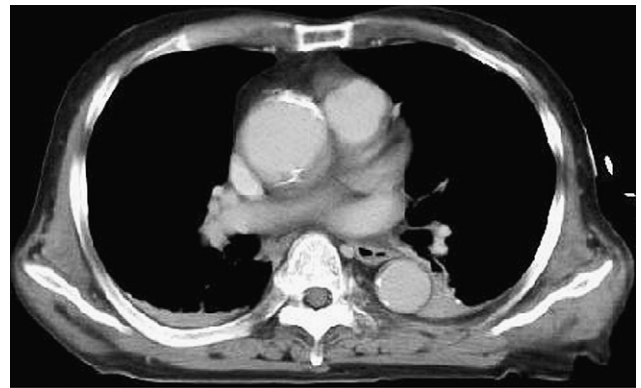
Chest computed tomographic scan (*top*) showing adventitial hematoma and a small ulcer with calcification in the posterior wall of the ascending aorta. A duplex scan (*bottom*) reveals a thrombus in the right internal carotid artery.
